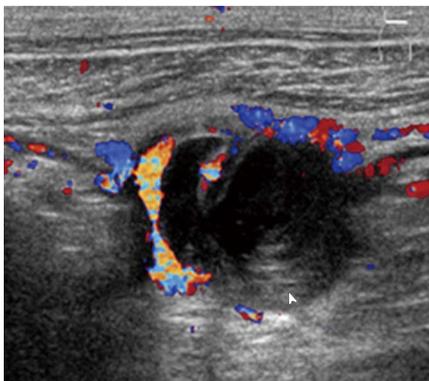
Mucocele of the appendix in a 54-year-old man. Ultrasound image shows an anechoic round mass in the appendix with echogenic layers (arrowhead) (the so-called “onion-skin” sign).
